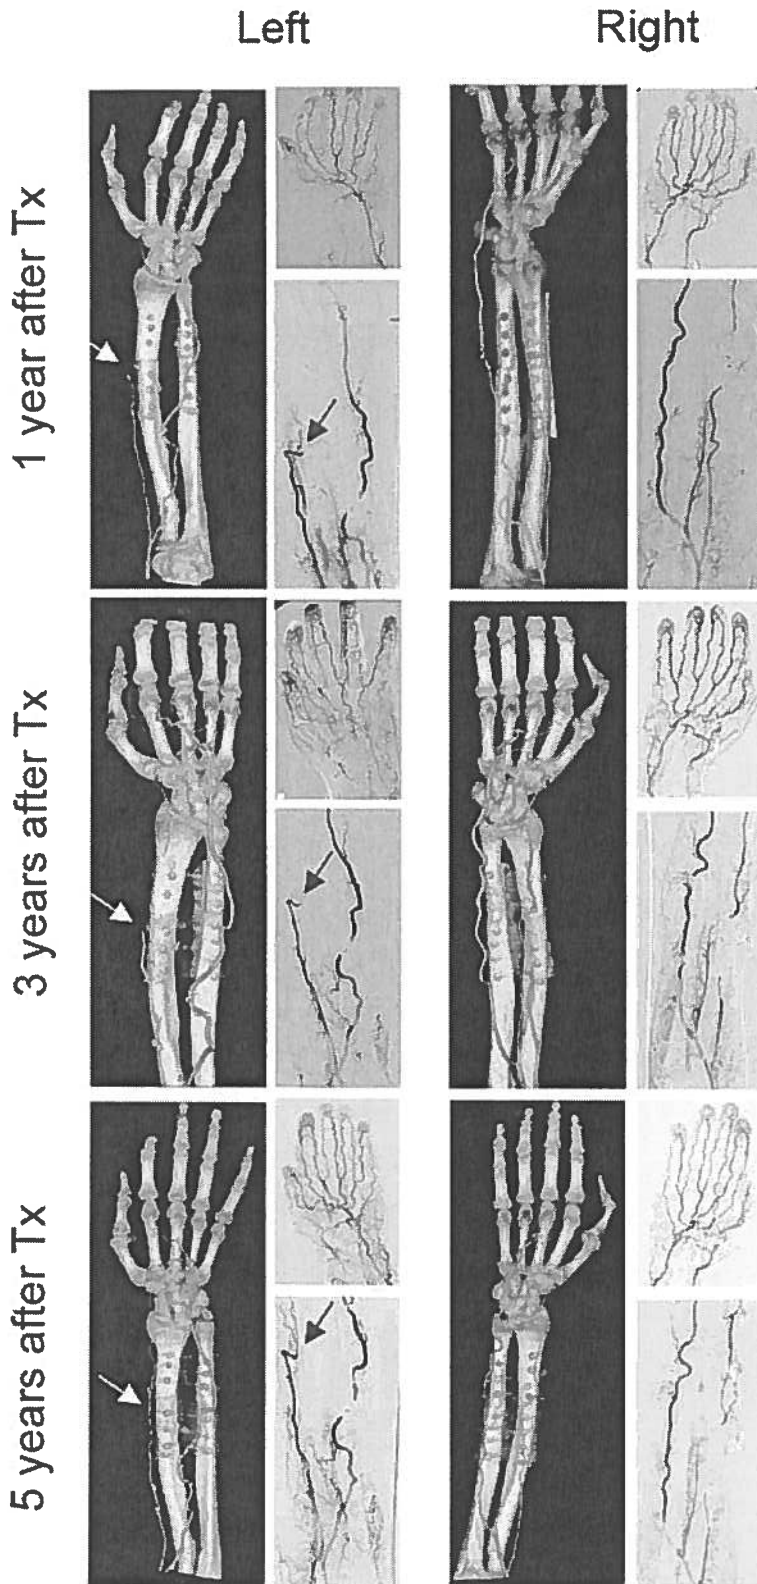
CT angiography and angiography at 1, 3 and 5 years after hand transplantation. The left radial artery was occluded early after transplantation (arrow). At 5 years after transplantation the vessel was found to be recanalized and orthograde blood flow was observed. Neither in larger nor in small vessels were signs of luminal narrowing or occlusion found at any time.
